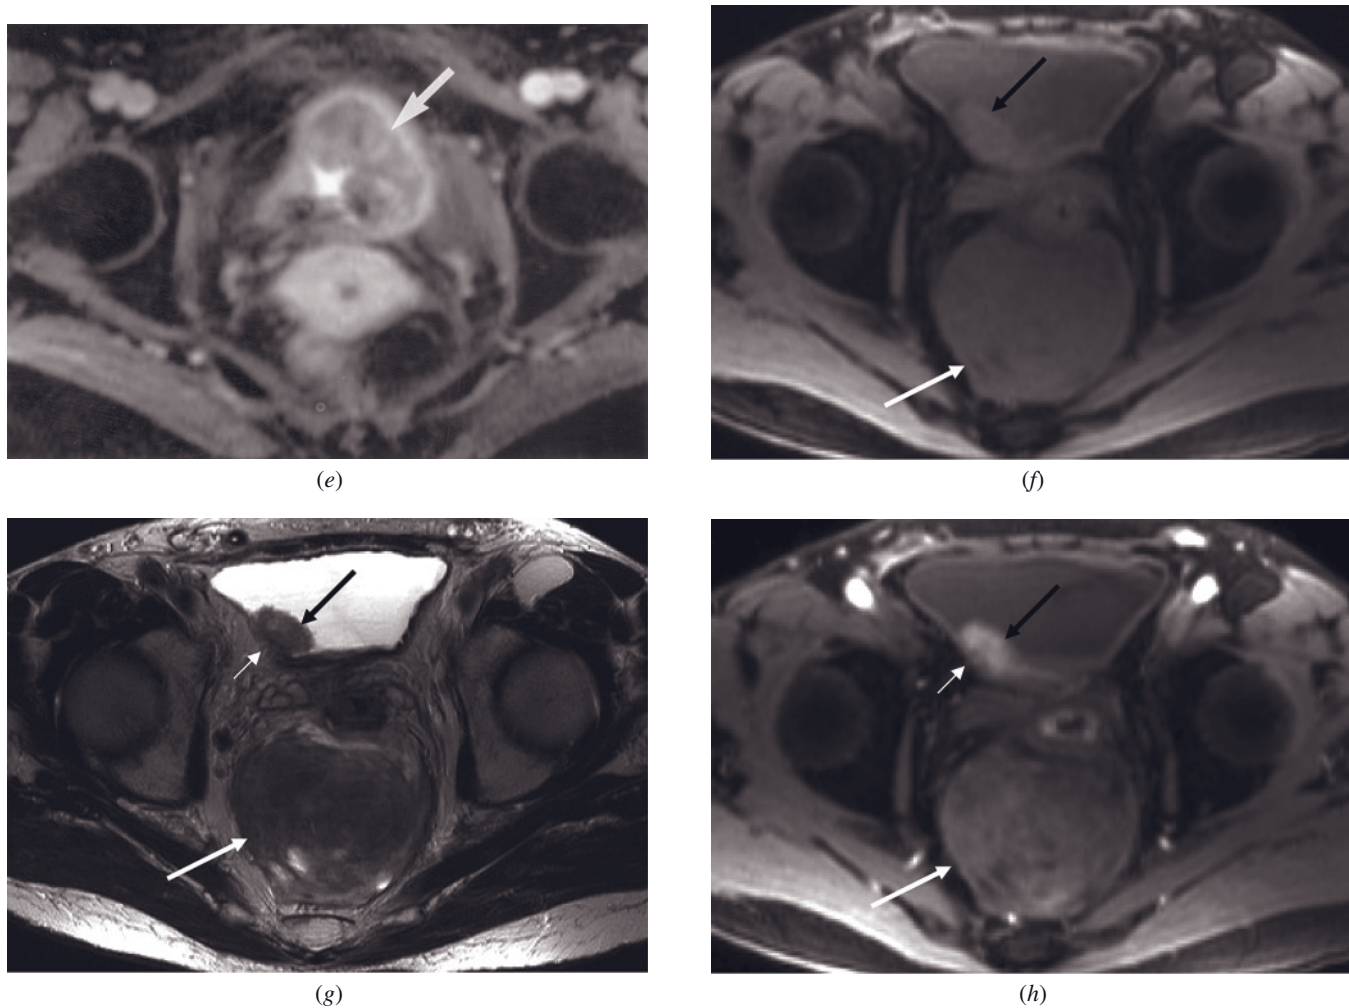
(Continued) gadolinium-enhanced fat-suppressed SGE image (*e*) in a third patient with rectal cancer involving the bladder. A large tumor mass is present (arrow, *e*), which fills much of the lumen of the bladder. T1-weighted fat-suppressed SGE (*f*), T2-weighted high resolution fast spin-echo (*g*), and T1-weighted immediate postgadolinium fat-suppressed 3D-GE (*h*) images in a patient with metastatic malignant melanoma. There is a large tumor mass (white long arrows, *f-h*) in the rectosacral space, which shows intermediate to mildly high signal on T1-weighted image (*f*), heterogeneously low signal on T2-weighted image (*g*), and heterogeneous enhancement on postgadolinium image. Additionally, there is another tumoral mass (black arrows, *f-h*) in the bladder lumen that invades the bladder wall (white short arrows, *g, h*) as well. This lesion shows signal and enhancement characteristics similar to the large tumoral mass located in the rectosacral space. The intermediate to mildly high signal on T1-weighted image suggests the diagnosis of malignant melanoma.
